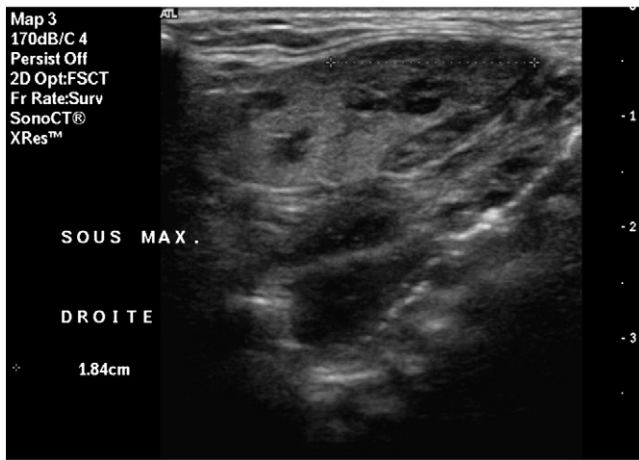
Heterogeneous texture and hypoechoic nodules were demonstrated in the right submandibular gland's ultrasound.
